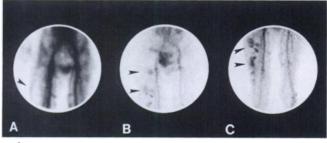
Anterior pelvis and proximal lower extremities scintigram after red-cell labeling with ^{99m}Tc. (A) Image at 60 min shows a large cold defect in the lateral aspect of the mid-right thigh (arrow) consistent with hematoma. At 24 hr, (B) and (C), multiple foci of increased uptake are identified within large hematoma compatible with active bleeding.
